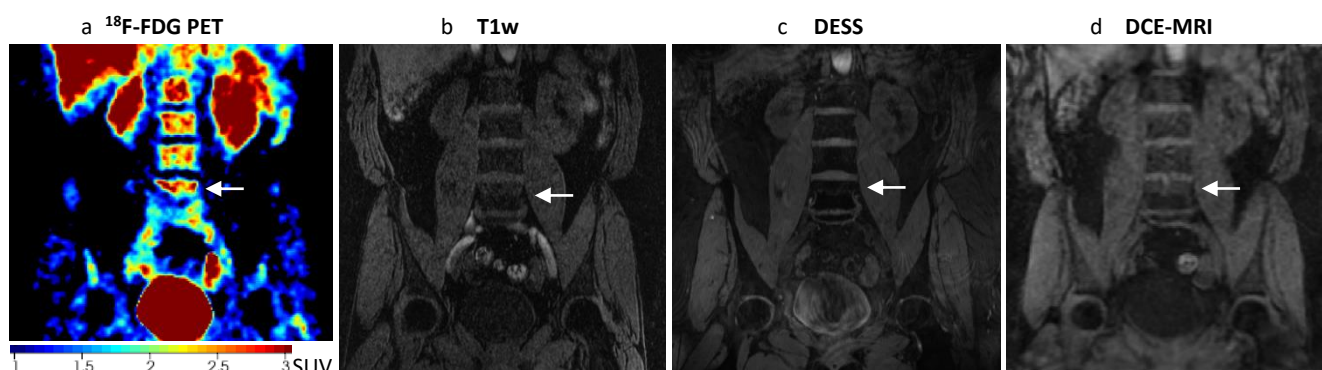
Coronal slices of images included in the PET/MRI acquisition protocol. The arrow indicates lumbar vertebra L5. a) ¹⁸F-FDG PET: ¹⁸F-Fluorodeoxyglucose positron emission tomography; b) T1w: T1-weighted fast spoiled gradient echo sequence, water image; c) DESS: double-echo steady-state; d) DCE-MRI: dynamic contrast-enhanced magnetic resonance imaging, water image
